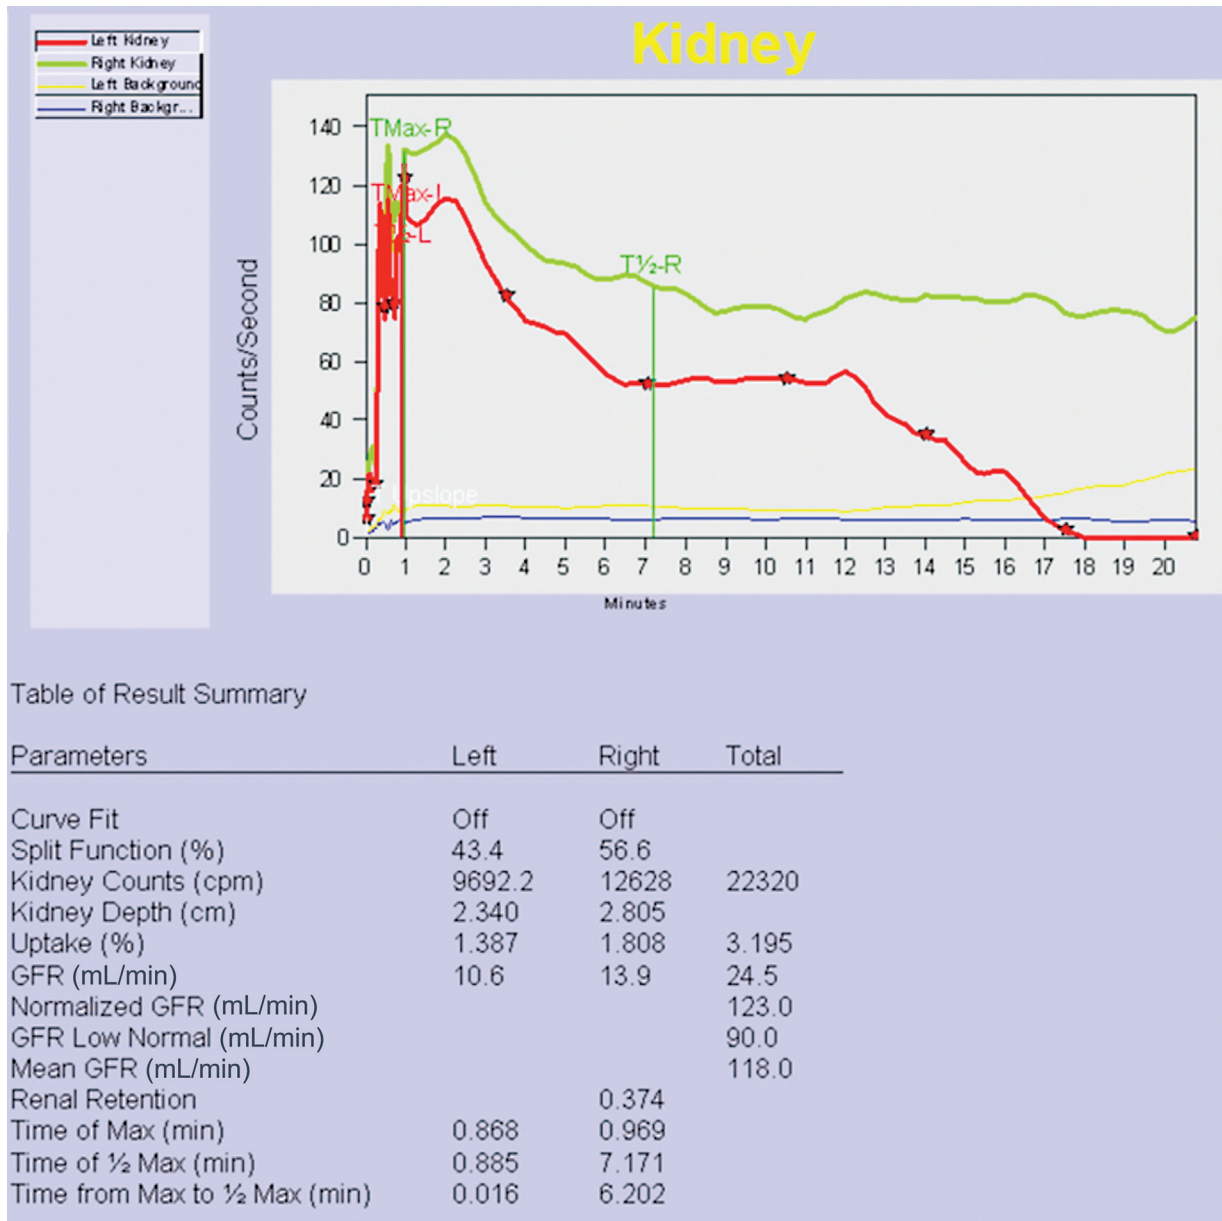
99mTc diethylenetriamine pentaacetate (DTPA) single-photon emission computerized tomography (SPECT) scan showing perfusion of both kidneys.
